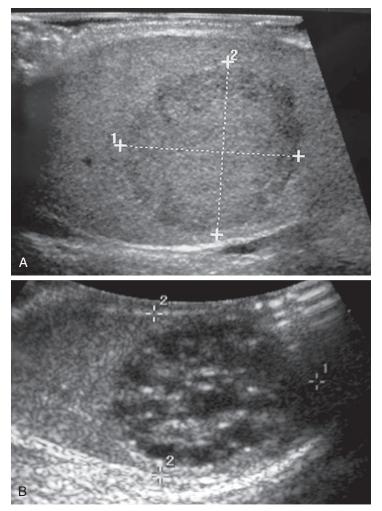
Testis tumor. A and B, Ultrasound examination of two patients with palpable testis tumors.
